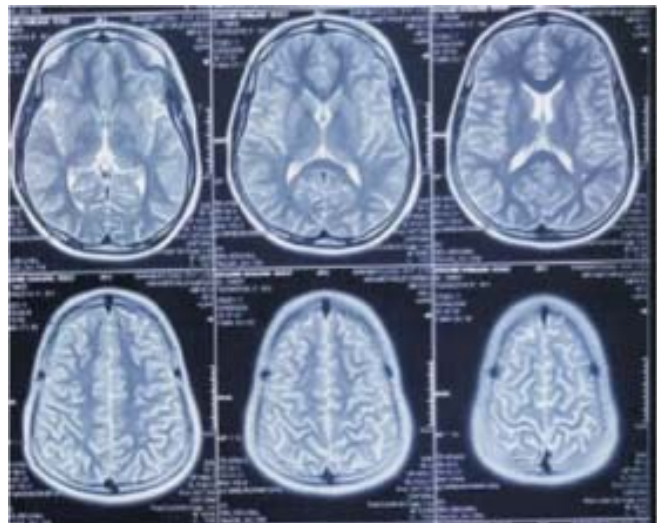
MRI Brain showing Demyelinating lesions.
